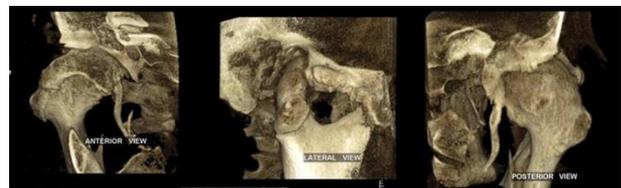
CBCT image shows radiopaque lesion in the right condyle
